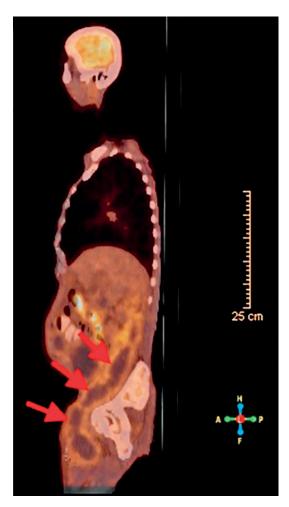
PET/CT showing inflammatory process that represents communication between the retroperitoneal and left femoral region.
